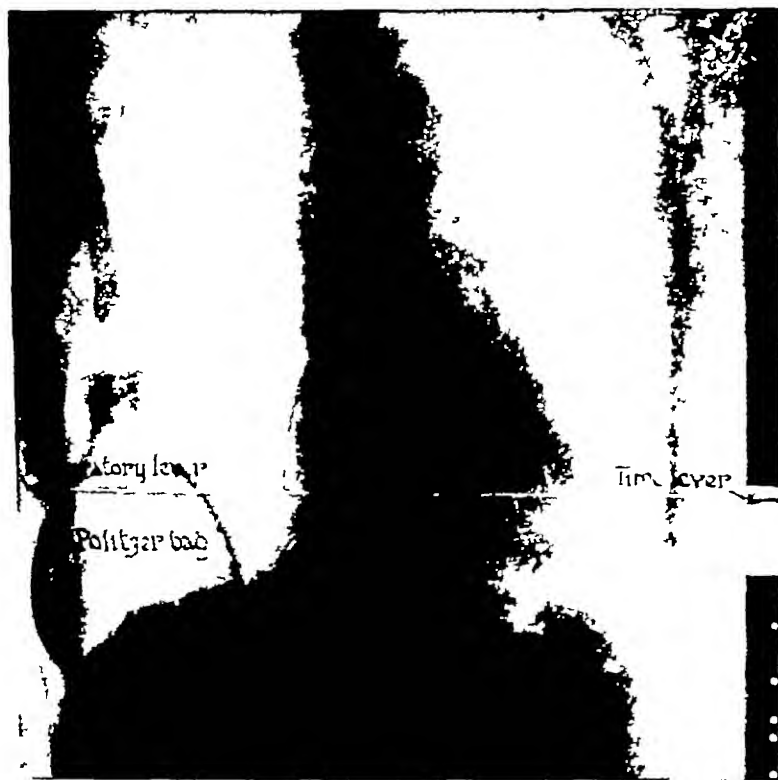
CONTROL PLATE SHOWING LEVEL OF THE RIGHT AURICULAR, AND OF THE LEFT VENTRICULAR MARGINS OF WHICH THE MOVING X-RAY FILMS WERE OBTAINED
